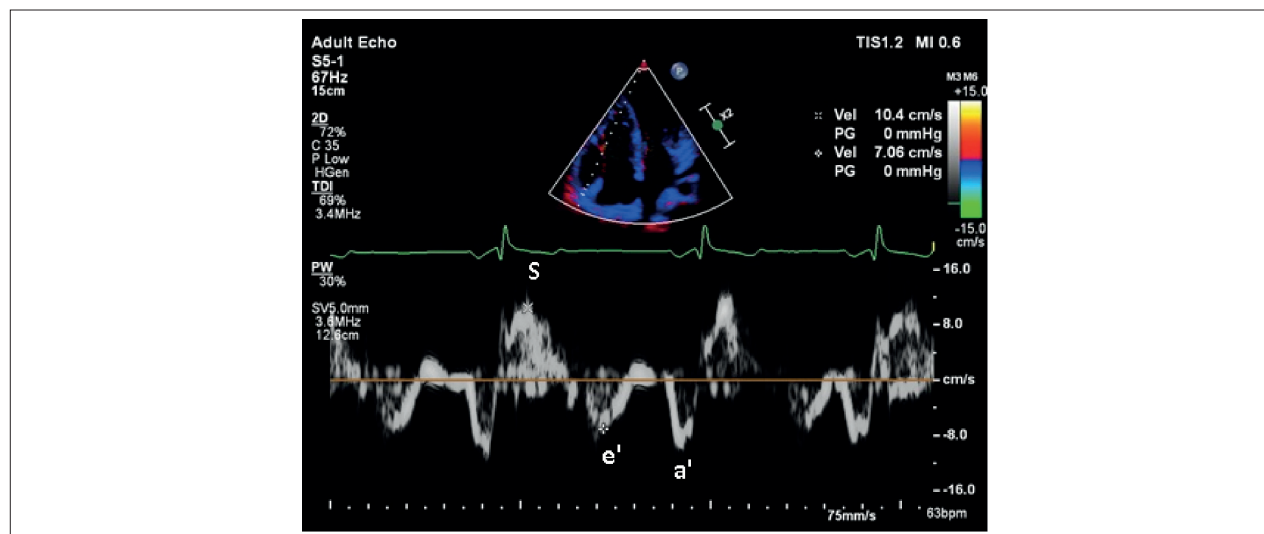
Tissue Doppler of right ventricular free wall with e' and S-wave velocities.
